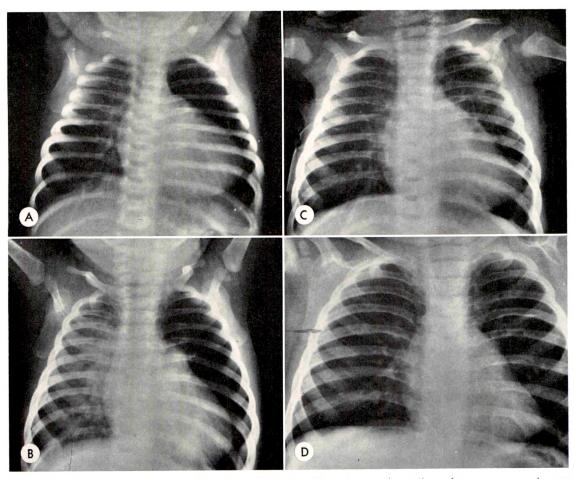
Case I. (A) Roentgenogram of the chest at the age of 6 weeks reveals cardiac enlargement, prominence of the pulmonary artery, overfilling of the intrapulmonary vessels in the right lung and a paucity of vessels in the left lung. Both lungs are overaerated. (B) Roentgenogram at 3 months of age reveals more marked alterations of the intrapulmonary vasculature. Postoperative roentgenograms (C) at 9 days and (D) at 8 months, respectively, reveal equal aeration of the lungs and equal intrapulmonary vasculature.
